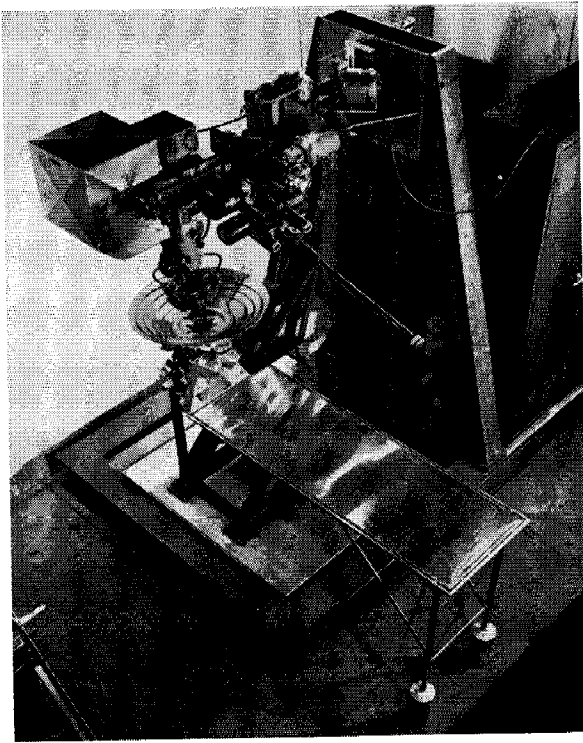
Over-all view of the transportable human ultrasonic neurosurgery instrument. The 4-beam focusing irradiator is shown in position above the pan which supports the transmitting liquid. The head holder lies beneath this coupling pan. The pan itself is provided with heat exchange coils which permit the temperature of the transmitting liquid to be maintained at the desired value. The positioning system which supports the 4-beam irradiator permits the focal spot of the irradiator to be moved about in three mutually perpendicular directions. One of the X-ray tubes which are used in the determination of the position of internal brain landmarks is shown mounted on the head holder. The operating table incorporated with the instrument is shown in position for irradiation of the patient from the lateral direction. The electronic instrumentation which supplies the electrical driving power for the irradiator and the instrumentation for calibration is shown behind the framework which supports the positioning system for the irradiator.*
